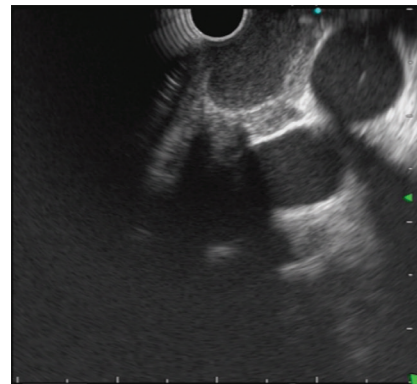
Endoscopic ultrasound examination from mid esophagus showing homogeneous hypoechoic node in left lower paratracheal region.
